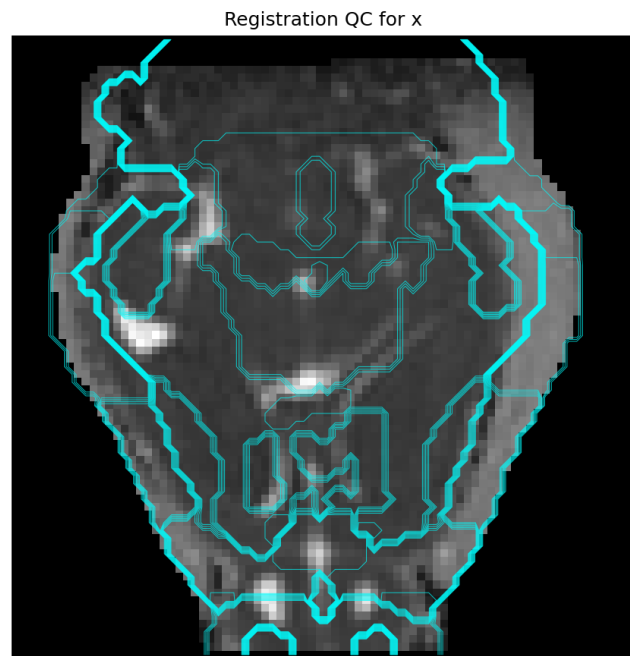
Visual quality control plot demonstrating accurate co-registration of the brain atlas (light blue outlines) to a representative b0-weighted MR image from one subject. This confirms reliable anatomical alignment, ensuring the integrity of regional brain morphometric feature extraction for all subsequent analyses.
